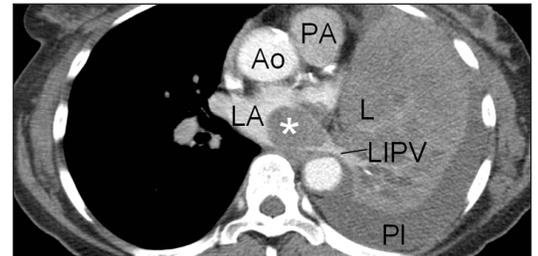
Axial contrast enhanced CT of the chest demonstrates a filling defect in the left atrium (*), left lung mass, left lung collapse, left pleural effusion, right breast mass (LA = Left Atrium; Ao = Ascending Aorta; PA = Pulmonary Artery; L = Left lung bronchogenic carcinoma; PI = Pleural effusion; LIPV = Left Inferior Pulmonary Vein; LV = Left Ventricle).
